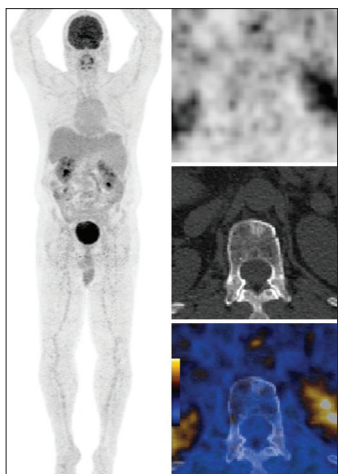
NaF-18-PET/CT images of the L1 lesion exhibit no FDG activity after XRT
